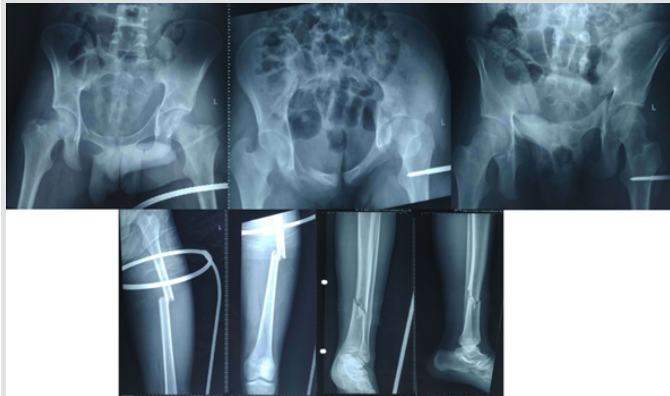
Pre-operative X-rays – anteroposterior, inlet and outlet views of pelvis, anteroposterior, and lateral views of femur and tibia showing sacroiliac joint disruption with transverse fracture of acetabulum, shaft femur, and shaft tibia fractures.
